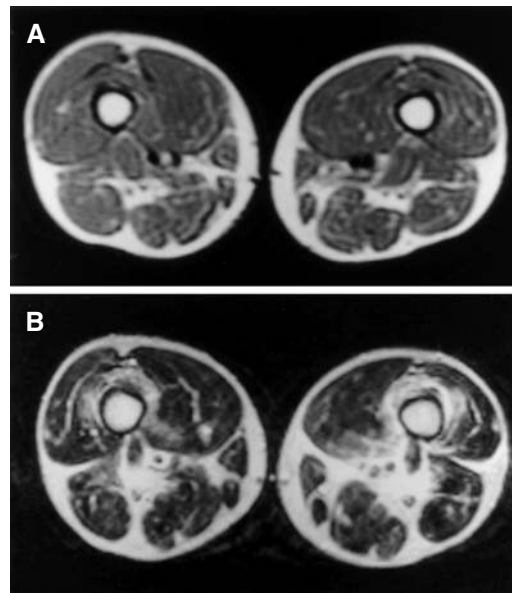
Magnetic resonance imaging of the thigh muscles in patient 2. A normal T1-weighted image (A) and a T2-weighted image (B) with high signal intensity in both vastus intermedius muscles are shown
